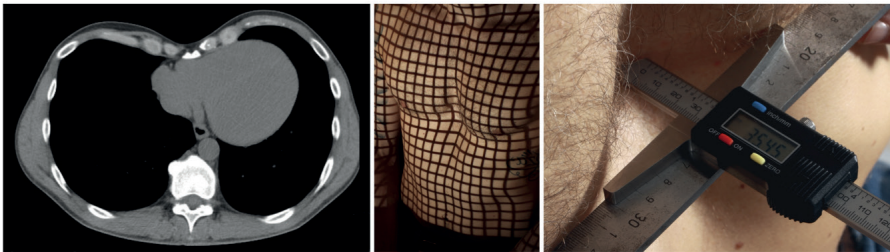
Patient C. Preoperative CT, 3D grid stereogram and digital measurement of external pectus depth.
